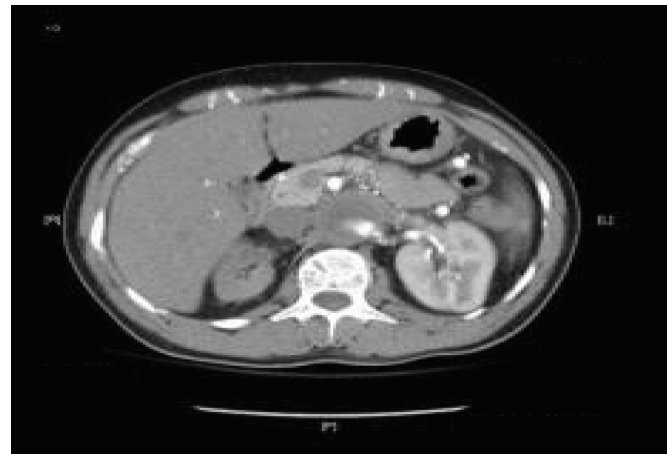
Computed tomography of abdomen—right kidney is smaller than the left
